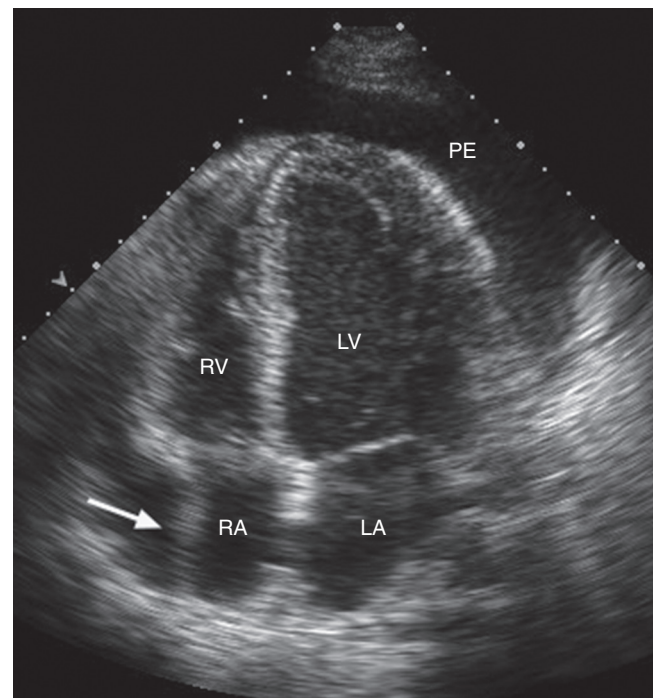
■ Circumferential pericardial effusion (PEF) with right atrial systolic collapse on the apical four-chamber view (arrow).
